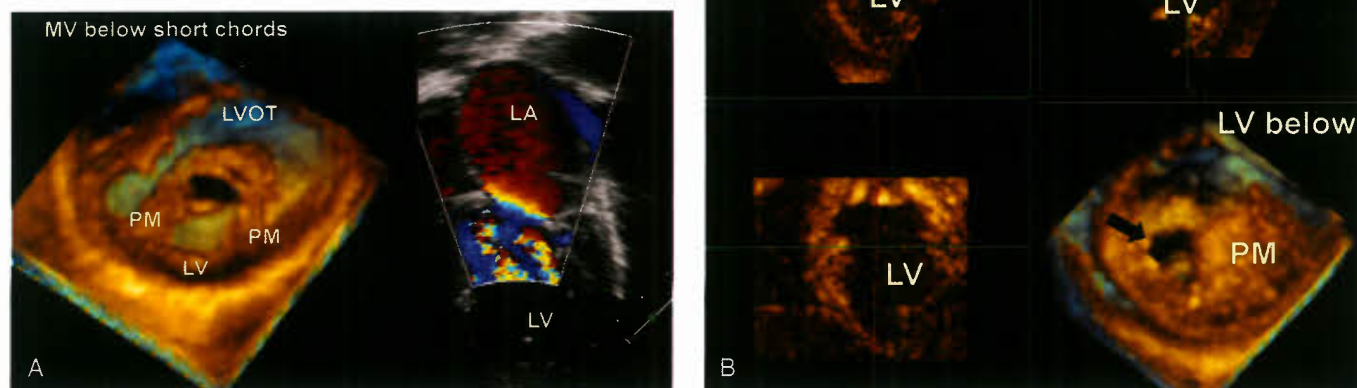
A: These images are from a case with MS due to shortened chordae and thickened leaflets. The 3-D image from below shows the thickened leaflets with shortened chordae. Note the orifice of the MV. The image on the right is a 2-D Doppler and shows the turbulent jet through the valve. LV, left ventricle; LVOT, left ventricular outflow tract; PM, papillary muscle. B: This montage is from a case with MV stenosis due to thickened chordae, with virtual fusion of the anterior papillary muscle to the leaflets, as seen by the lower right hand 3-D echo. The upper left hand image shows the 2-D appearance of the anterior papillary muscle and leaflet. The restrictive functional orifice is clearly seen in the lower right hand panel (black arrow). LV, left ventricle; PM, papillary muscle.
